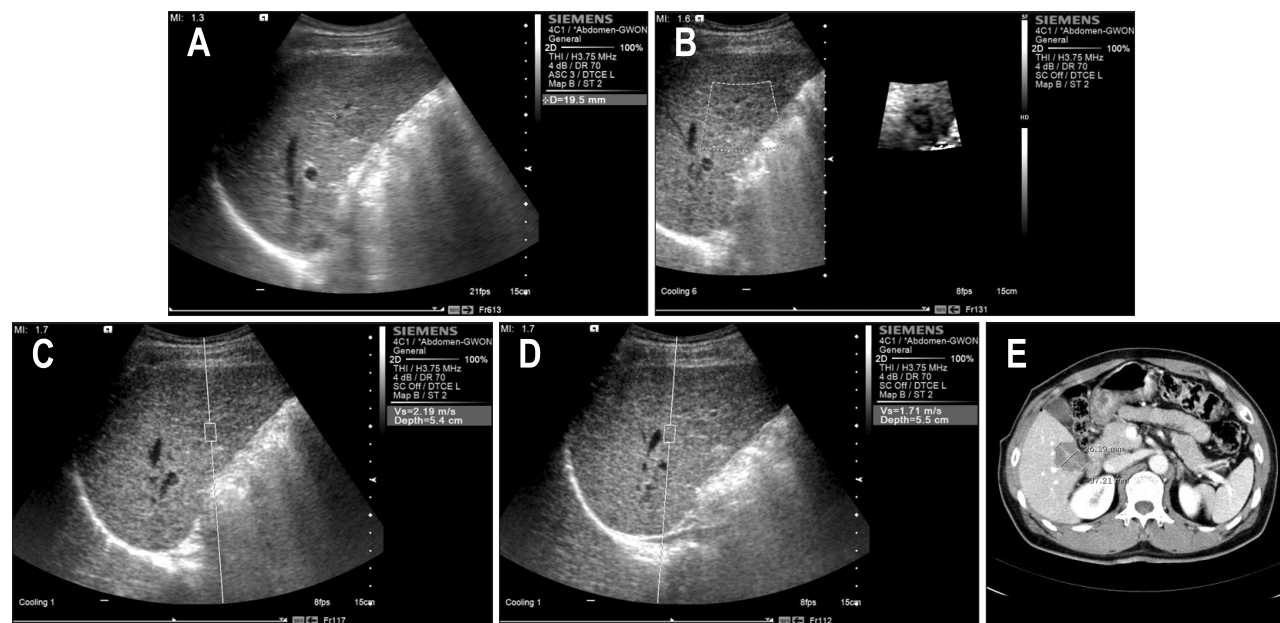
Hepatocellular carcinoma (HCC) and underlying LC in S5 in the liver of a 56-year-old man. HCC and underlying liver cirrhosis in S5 of liver in a 56-year-old man. (A, B) On a B-mode image obtained using a 4-MHz curved array, the HCC appears as a well-defined, hypoechoic mass approximately 19.5 mm in size, located in the S5 segment of the liver. The HCC appears as dark coloration on real-time acoustic radiation force impulse imaging. (C, D) Measurement of shear wave velocity of the HCC and hepatic parenchyma at similar region of interest depths (5.4 and 5.5 cm below the skin) reveals that stiffer tumors display greater velocity (2.19 m/sec) than cirrhotic parenchyma (1.71 m/sec). (E) Post-radiofrequency ablation computed tomography scan in the arterial phase displays an oval, well-ablated and necrotic alteration in the HCC, which was $(3.7 \times 2.6 \times \pi/4)$ cm² in size.
